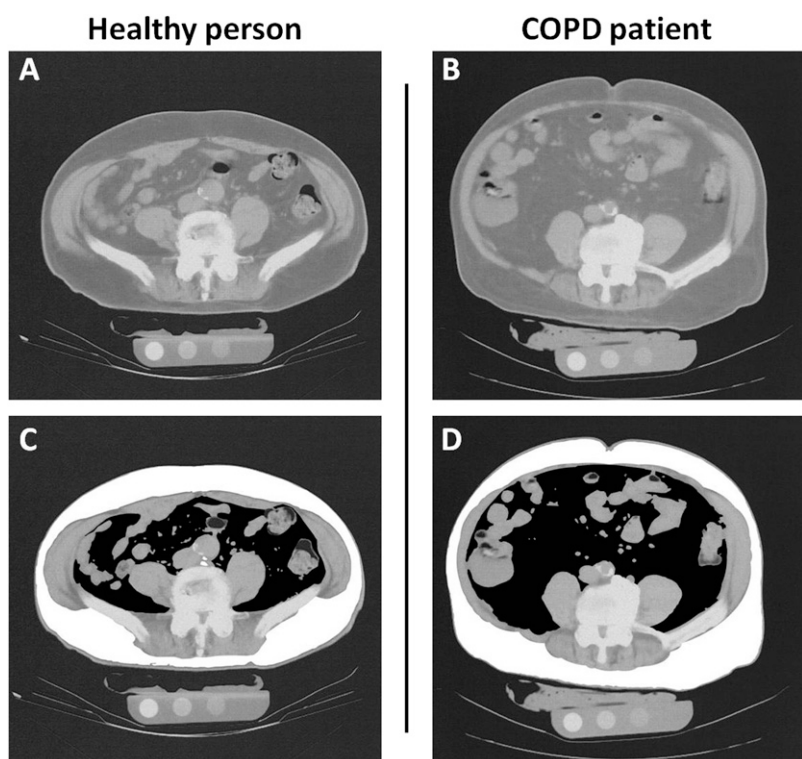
Excessive visceral fat accumulation but normal subcutaneous fat content in chronic obstructive pulmonary disease (COPD). Abdominal computed tomography (CT) scans from (A) a healthy person and (B) a patient with COPD (FEV₁, 53% of predicted) matched for age, sex, and body mass index (29 kg/m²). The *black* and *white* areas in C and D denote the visceral and subcutaneous fat compartments, respectively. Pictures show representative CT scans from a previous study (28).
